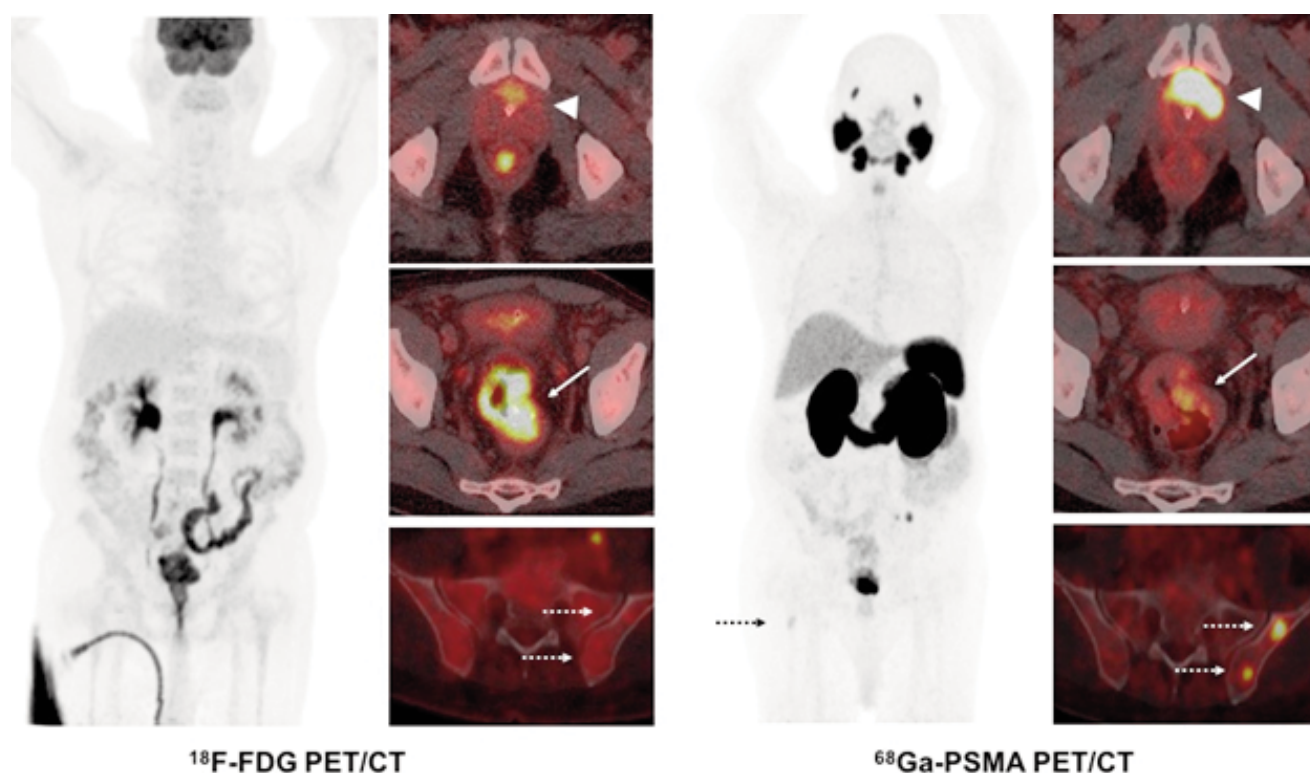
^{18}F -FDG PET/CT demonstrated an intensely FDG-avid primary rectal tumor (solid arrow) with suspicious mesorectal lymph nodes. Additionally, mild heterogeneous FDG uptake was noted within an enlarged prostate gland (arrowhead) with high PSA level of 43ng/mL, raising suspicion for a synchronous prostatic malignancy. Subsequent ^{68}Ga -PSMA PET/CT revealed intense ^{68}Ga -PSMA uptake in the prostate (arrowhead) consistent with primary prostate carcinoma, along with PSMA-avid (FDG non-avid) osseous lesions in the left iliac bone and upper shaft of the right femur (dotted arrow), compatible with skeletal metastases of prostatic origin.
